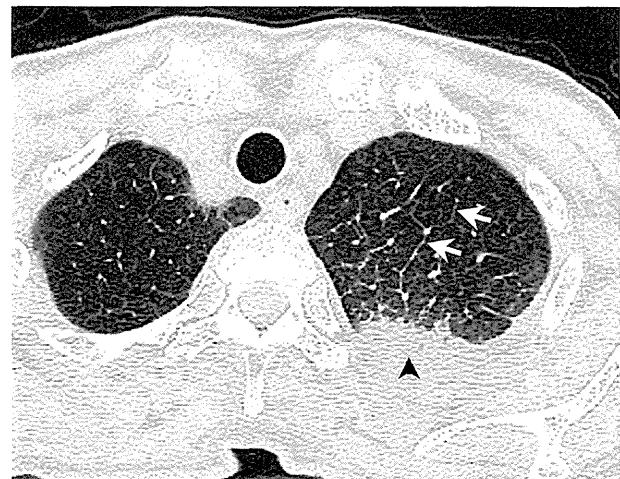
Acute transformation (acute type) in a 77-year-old female patient with smouldering type ATLL, 7 days after the onset of fever and general fatigue. Transverse CT image (1-mm thickness) at the level of the left upper lobe shows consolidation (arrowhead), GGO and interlobular septal thickening (arrows)
